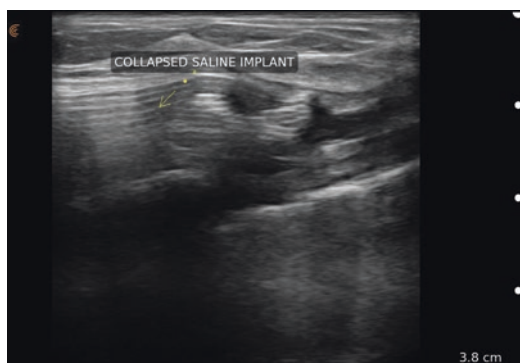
Grayscale ultrasound image showing a saline breast implant that has collapsed with loss of most of its saline volume
